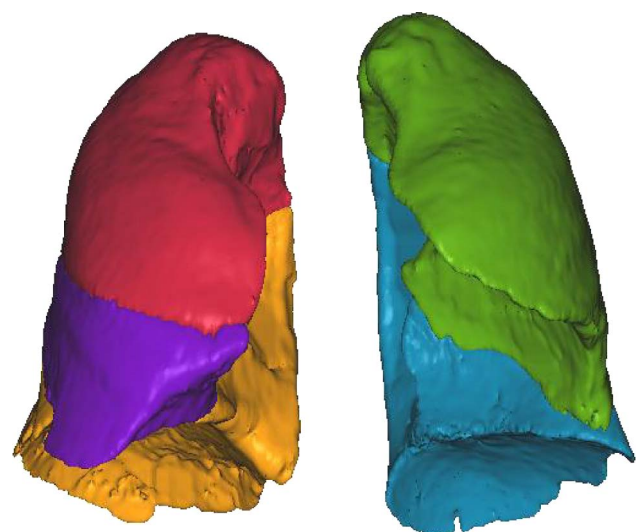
Example of a segmented CT examination used to derive CT total lung volume (TLV_{CT}). The lobes are shown in different colours.
